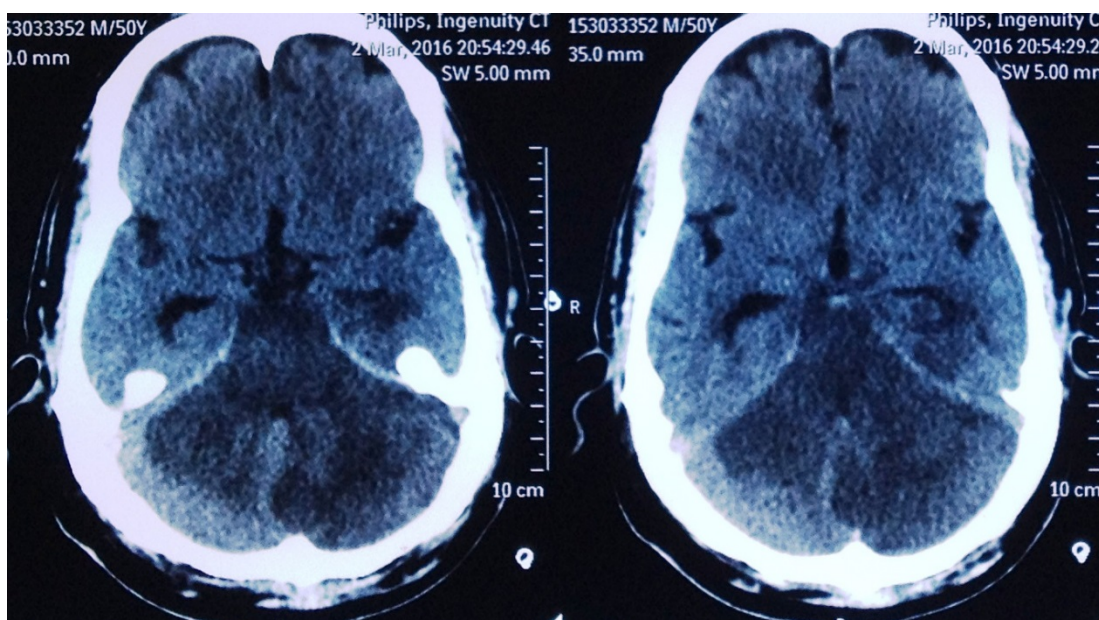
Computed tomography brain showing large acute infarcts involving bilateral cerebellar hemispheres and brain stem
